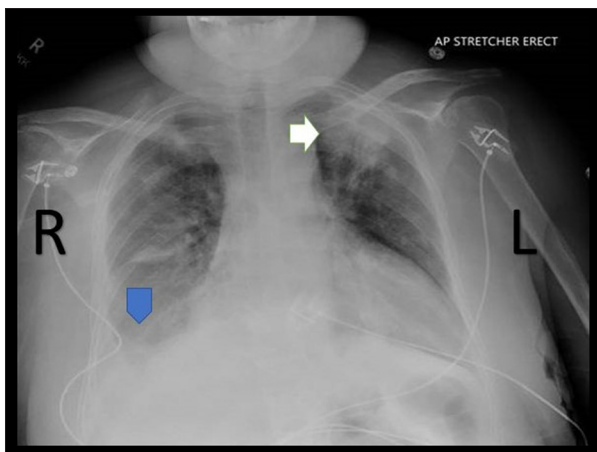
Chest X-ray in a patient with disseminated nocardiosis. The chest X-ray shows right lobe consolidation (arrow) and right-sided pleural effusion (arrow head).
